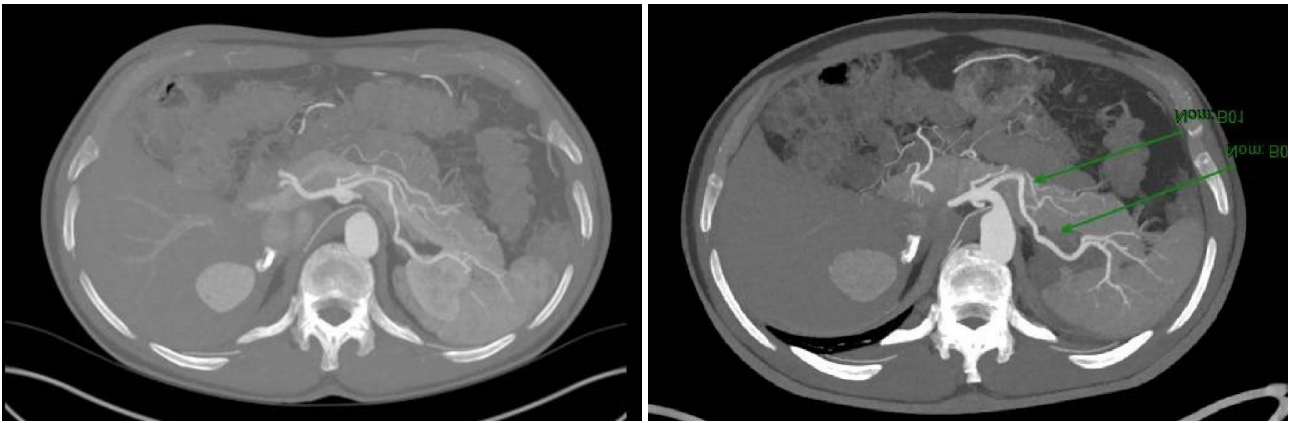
Three- and six-months follow-up. CT shows progressive improvement of the splenic arterial caliber and decreased arterial wall circumference (arrows).
